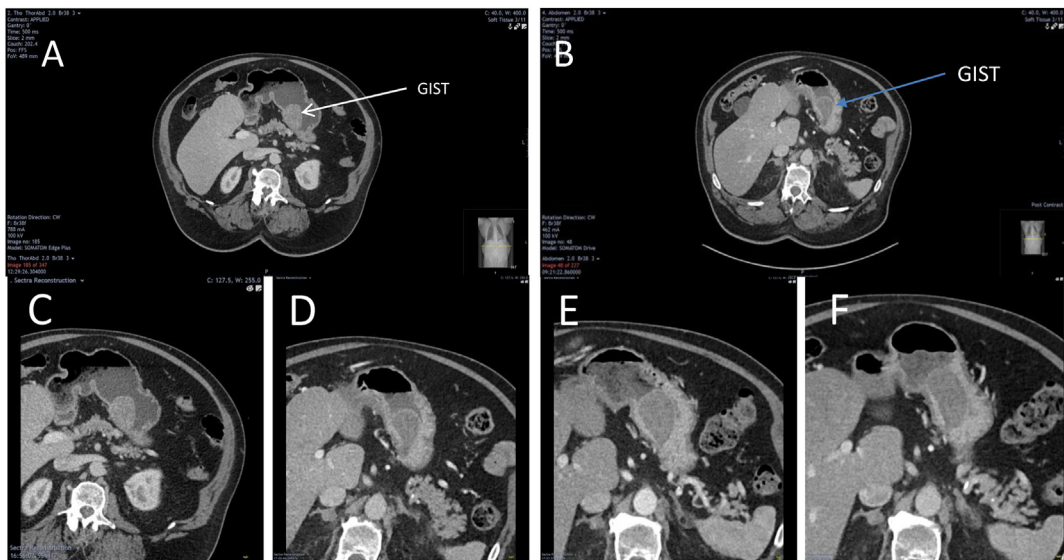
Computed tomography for GIST. An exophytic mass visible within the stomach from the lesser curvature measuring 46 × 30 mm appears relatively well-defined and has no convincing abnormality in the adjacent fat (A and B). The lesion demonstrated a ≥15% decrease in tumor attenuation fulfilling the Choi response criterion for PR in each scan taken 6 months apart (C, D, E, and F). GIST: Gastrointestinal stromal tumor; PR: Partial response.
